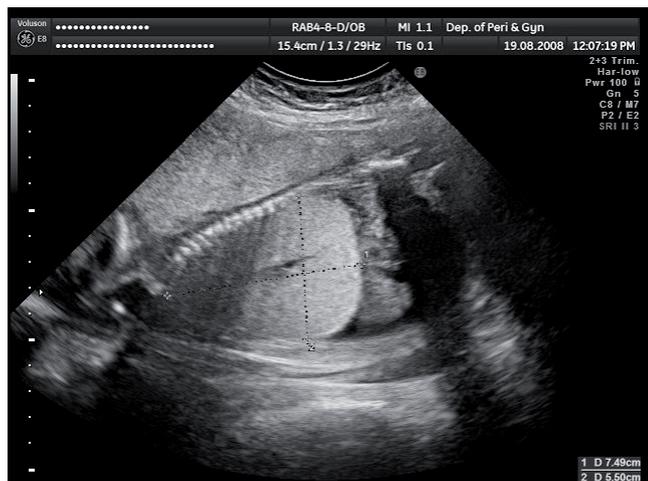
Ultrasound image of fetal thorax and abdomen in sagittal plane in 23 weeks' gestation shows enlarged, hyperechogenic lungs, everted diaphragms and massive ascites.
